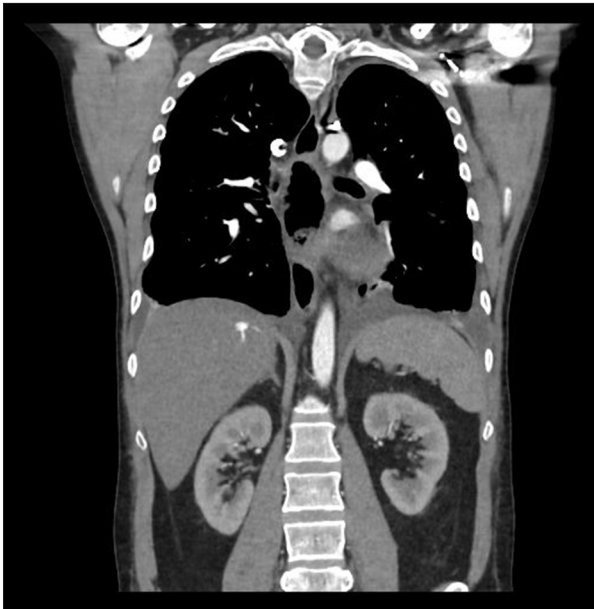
CT scan showing abnormal dilatation of the esophagus in the retrocardiac portion suggestive of previous fistula.
